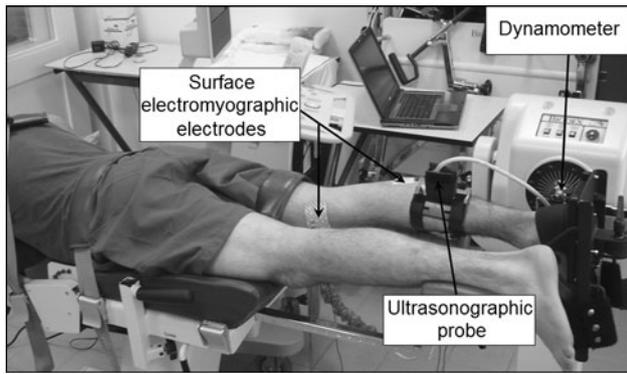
Subject position during ankle passive stretches. A computer recorded simultaneously electromyographic, ultrasonographic and mechanic data
